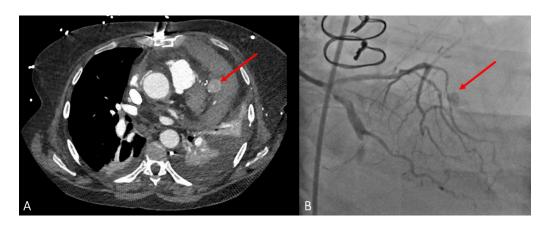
(A) Computed tomography arteriogram (CTA) image. The red arrow indicates pseudoaneurysm originating on the left lateral aspect of the heart with possible active extravasation. (B) Coronary angiogram with the red arrow demonstrating a pseudoaneurysm originating from a diagonal branch of the LAD.
